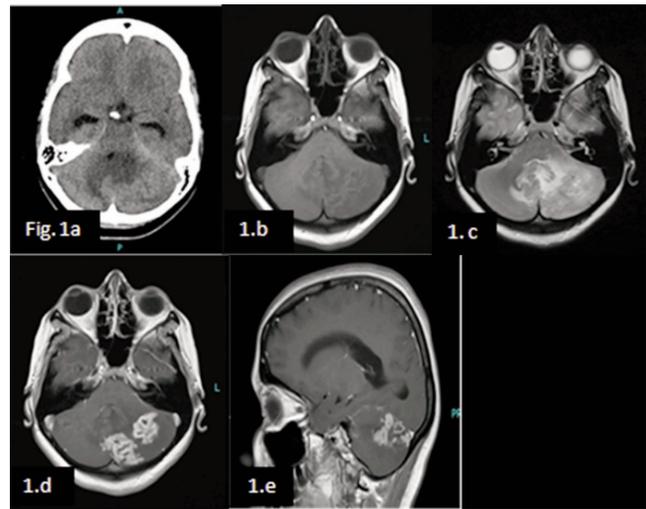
(a) Non-contrast CT Scan showed hypodense areas in the cerebellum and prominent temporal horns of lateral ventricles. (b) MRI, T1-Weighted axial image: shows hypointense areas in left cerebellum and vermis. (c) T2-Weighted axial image: iso to hyperintense lesions in left cerebellum and vermis with marked surrounding oedema. (d) Contrast enhanced axial T1-Weighted image: shows heterogenous enhancement of the lesions. (e) Contrast enhanced T1-Weighted sagittal image showing multiple enhancing lesions in left cerebellar hemisphere.
